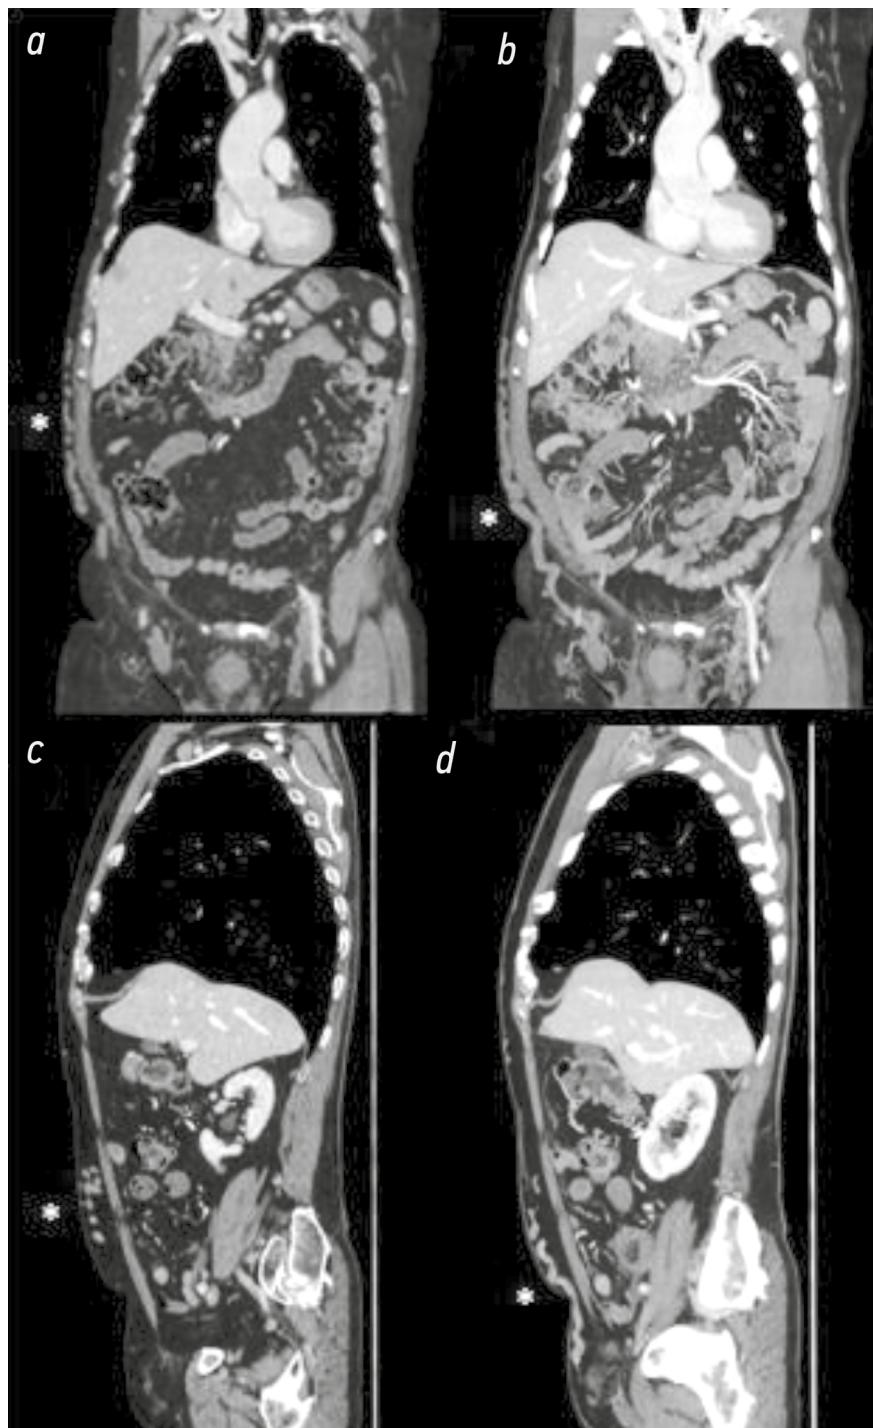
Computed tomography images of the coronal (up) and sagittal (down) sections in the portal phase of the chest and abdomen: *a*) Right abdominal wall: consistent venous collateral circles are visible (white asterisk). *b*) The same image with a rising MIP value indicates venous collateral rings, particularly on the patient's right side. *c*) and *d*) Hypertrophic venous collateral circles in the sagittal section at different levels.
